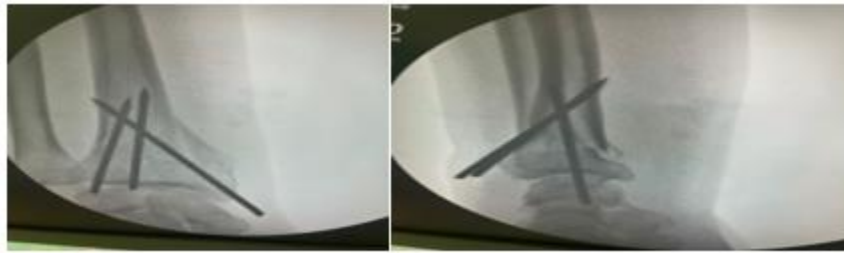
wrist X-Rays percutaneous pinning
